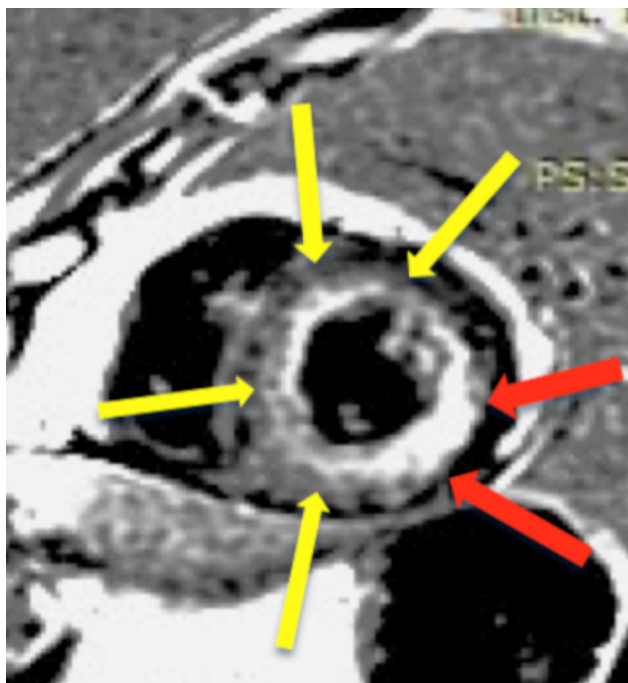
Follow-up cardiac magnetic resonance imaging showing LGE with subendocardial (yellow arrows) and transmural distribution (red arrows). The LGE distribution at 1-year was similar to the initial investigation.
